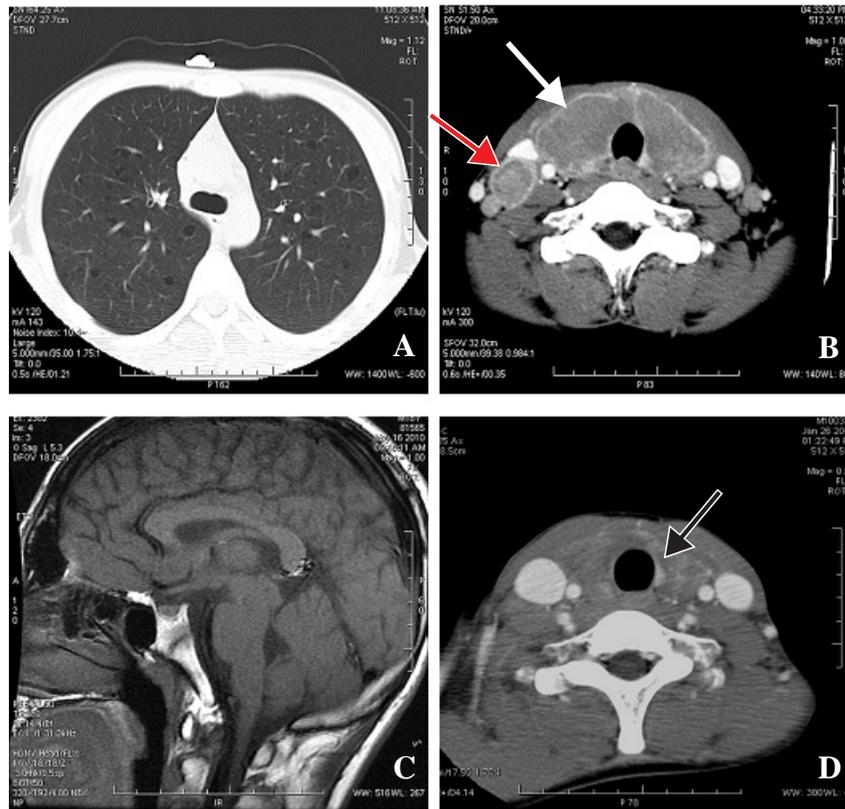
Imaging examination of the patient. A: Before chemotherapy, CT scan of chest showed multiple thin-walled cavitated nodules in both lungs. B: Before chemotherapy, contrast-enhanced CT scan of thyroid showed enlarged thyroid with multiple lymph nodes. The white arrow represented enlarged thyroid, the red arrow represented confluent lymph nodes. C: Before chemotherapy, MRI image of pituitary revealed absent posterior pituitary bright spot on T1 weighted images. D: Three months after nine cycles of chemotherapy regimen with vincristine plus prednisone, contrast-enhanced CT showed thyroid was significantly shrunk (the black arrow showed), without any enlarged lymph nodes.
